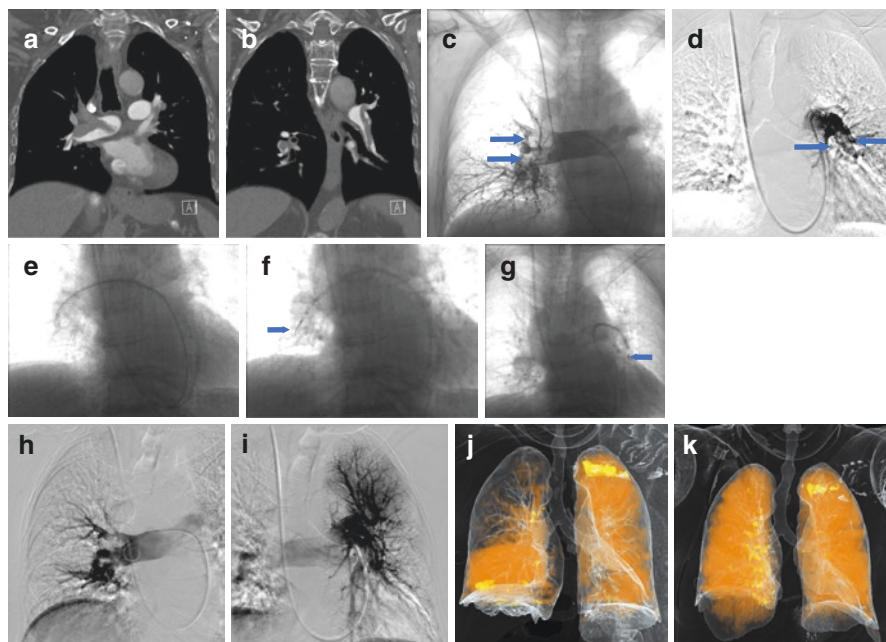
Images from a 75-year-old woman with a history of remote benign intracranial mass resection who was brought to the emergency department after a fall associated with 3 days of worsening dyspnea; she was found to have an intermediate-risk PE (a, b) Coronal sections of a CT pulmonary angiogram showing acute pulmonary emboli within the right main (a) and left lobar (b) pulmonary arteries. (c, d) Via right internal jugular venous access, diagnostic catheter angiograms of the right (c) and left (d) pulmonary arteries were performed localizing occlusive thrombus in the right main pulmonary artery and left lower lobe pulmonary artery (arrows). (e) An 8-F vascular sheath was positioned in the pulmonary trunk to facilitate catheter-directed thrombolysis. (f, g) An Indigo CAT8 (Penumbra, Inc.) mechanical thrombectomy catheter was advanced through the vascular sheath and manipulated within the right (f) and left (g) pulmonary arterial trees to macerate occlusive thrombus (arrows). (h, i) Repeat catheter angiography of the right (h) and left (i) pulmonary arterial trees revealed decreased clot burden. (j, k) Preprocedure (j) and postprocedure (k) dual-energy CT pulmonary blood volume iodine maps revealing improved perfusion of the right upper lobe and left lower lobe. The patient tolerated the procedure well and was discharged on the sixth postprocedure day on lifelong anticoagulation
